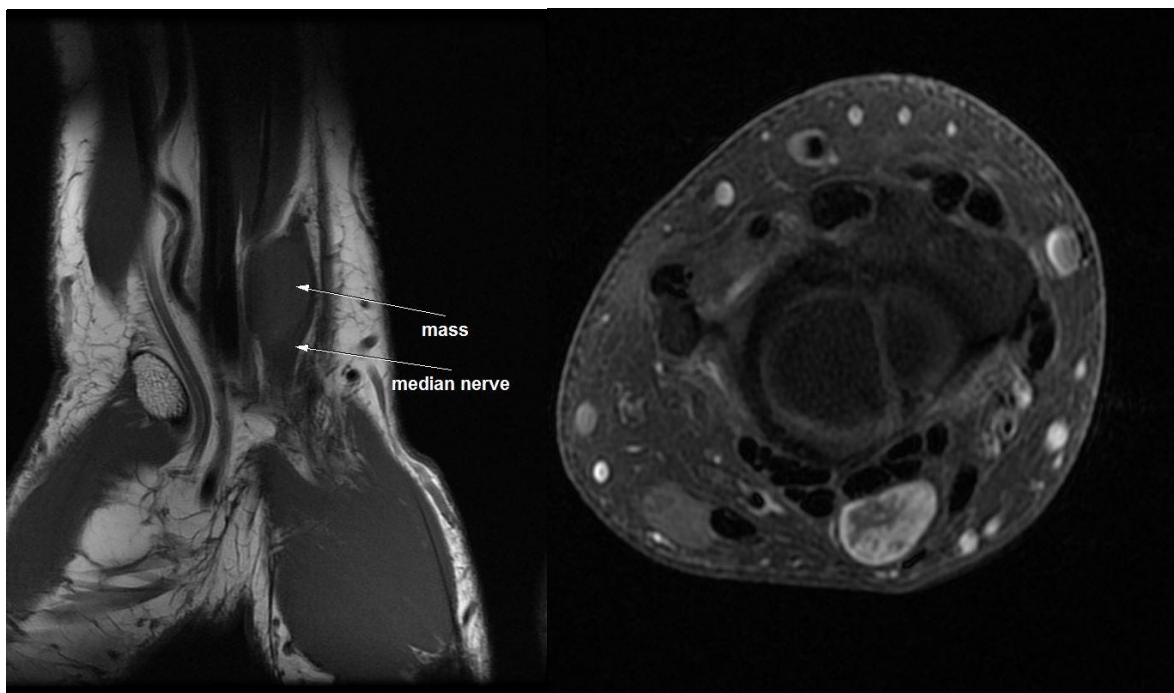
MRI of the Wrist in T1 Weighted Sequence in Sagittal Plan (A) and on T1 FATSAT Sequence after Gadolinium Administration in Axial Plan (B) Showing an Encapsulated Mass with an Heterogenous Enhancement after Gadolinium Administration.
